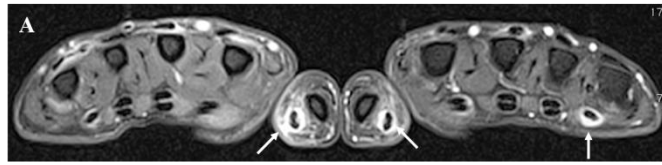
Bilateral magnetic resonance imaging (MRI) and ultrasound (US) of the hand and wrist of a 49-year-old woman with early inflammatory arthritis with a disease duration of 9 months; she fulfilled the criteria for rheumatoid arthritis at presentation. (A) Axial T1 fat-sat sequence after intravenous contrast administration showing grade 2 (≥ 2 and < 5 mm synovial proliferation with enhancement) tenosynovitis of the flexor tendons of the first digit on the right and of the first and fifth digits on the left (arrows). (B) Coronal T1 fat-sat sequence after intravenous contrast administration demonstrating enhancement of bilateral carpal joint synovitis (arrows). (C) Ultrasound examination of the fifth digit on the left demonstrating tenosynovitis (arrows) and active power doppler signal (dashed arrows). (D) Maximum intensity projection of a 3D digitally subtracted dataset of the VIBE acquisition after contrast administration, demonstrating increased vascularity of synovitis of carpal, metacarpophalangeal and interphalangeal joints. The tube-like appearance of digit tenosynovitis is also clearly depicted.
